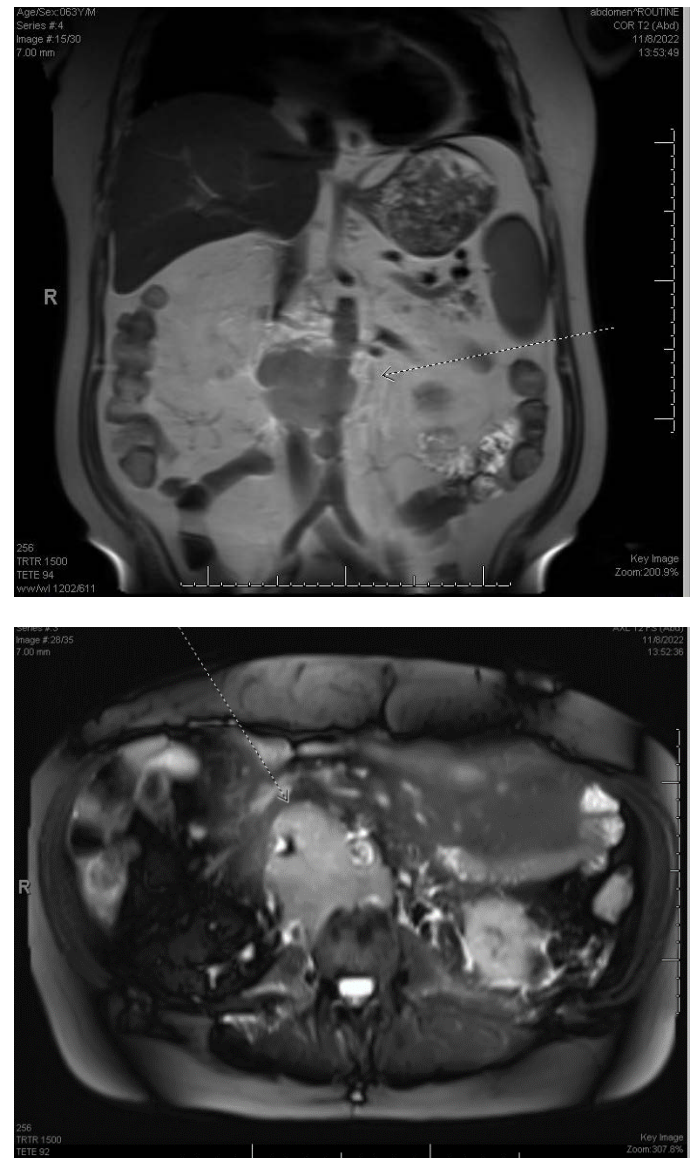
MRI Abdomen w/ w/o contrast (frontal and transverse). 7.9 x 7.1 cm retroperitoneal abnormality, encasing the inferior vena cava and most encasing the abdominal aorta. Findings likely represent retroperitoneal lymphadenopathy, possibly from lymphoma.
